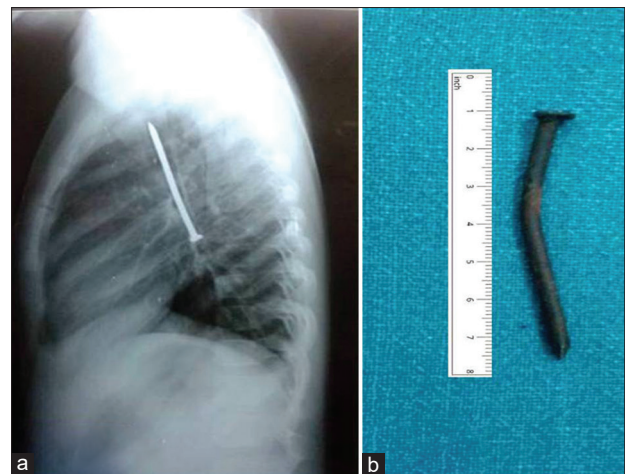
(a and b) X-ray chest showing a sharp elongated FB in the trachea; (b) an iron nail removed from the trachea
